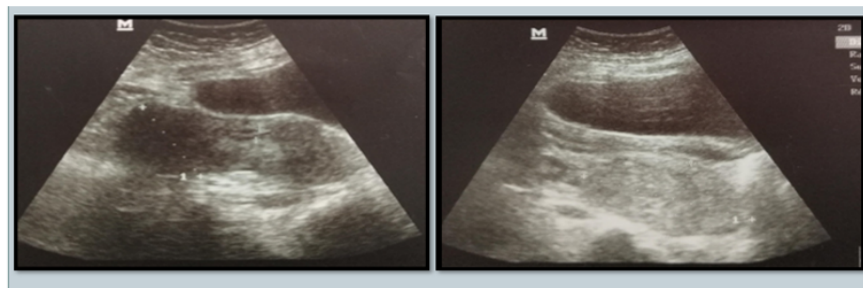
Ultrasound image.
